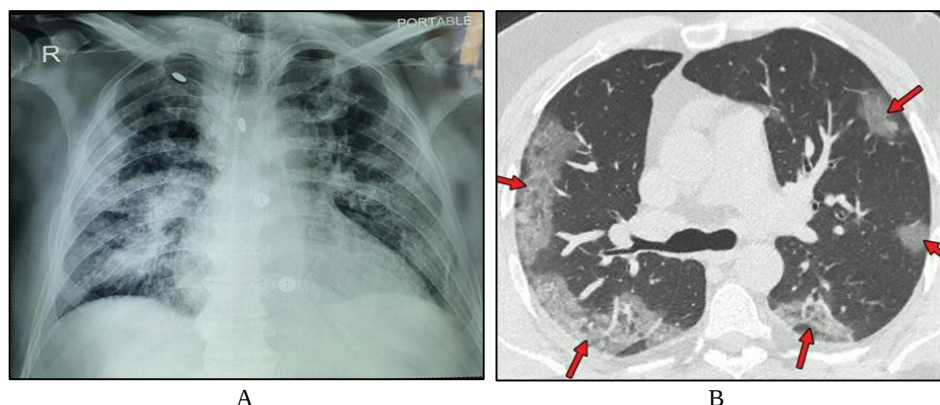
(A) Representing the chest X-ray (Antero-Posterior view) of a severely affected 52-years old male COVID-19 patient, showing the patchy consolidations and fibrosis in both lungs predominantly in lower zones. (B) A 47-year-old man with positive RT-PCR test results for SARS-CoV-2, showing bilateral areas of ground-glass opacities (Red arrows) in a peripheral distribution [20].
